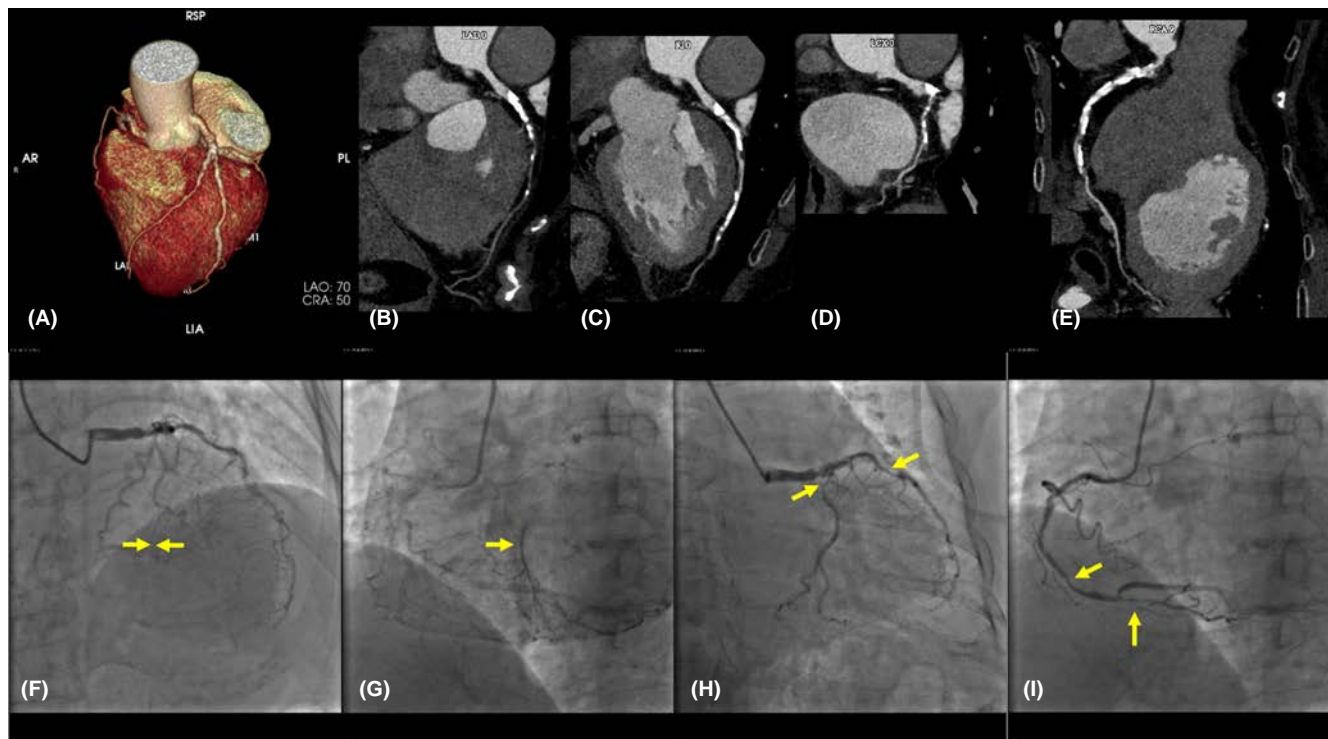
Images for 3-vessel disease in a 59-year-old woman with systemic lupus erythematosus for 19 years who presented with chest pain and hypertension for 10 years. Reconstructed imaging of coronary computed tomographic angiography (CTA) (A); CTA demonstrates severe calcification in the left anterior descending coronary artery (LAD) (B), intermediate (C), right coronary artery (RCA) (E), and moderate calcification in the left circumflex coronary artery (LCX) (D). Invasive coronary angiography shows occlusion of LAD (F), totally occluded LAD reinjected by RCA (G), significant stenosis of LCX and moderate stenosis of intermediate (H), and multiple stenosis of RCA (I) (yellow arrows)
